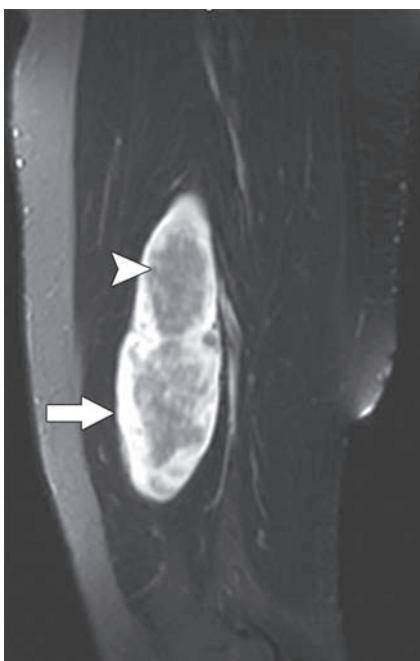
Nerve sheath tumor. Sagittal T2-weighted fat-saturated MR image shows a fusiform mass in the thigh. The mass has central low signal intensity secondary to increased collagen content (arrowhead) and peripheral high signal intensity (arrow), which produce a target appearance.
